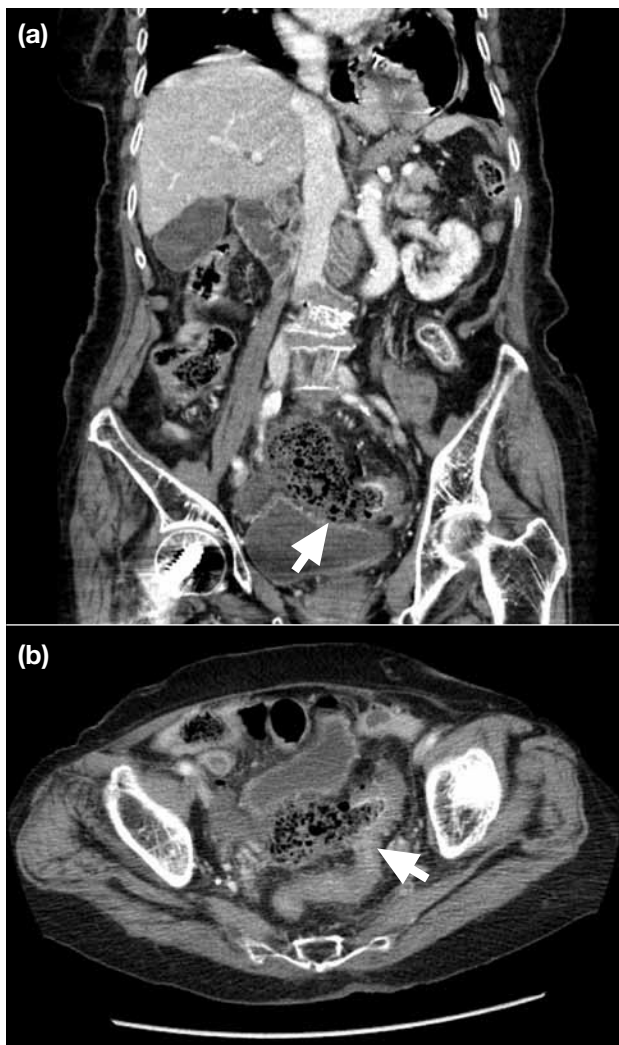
Reconstructed coronal computed tomography shows a faecaloma protruding through the perforation site (arrows): (a) coronal and (b) axial views.
